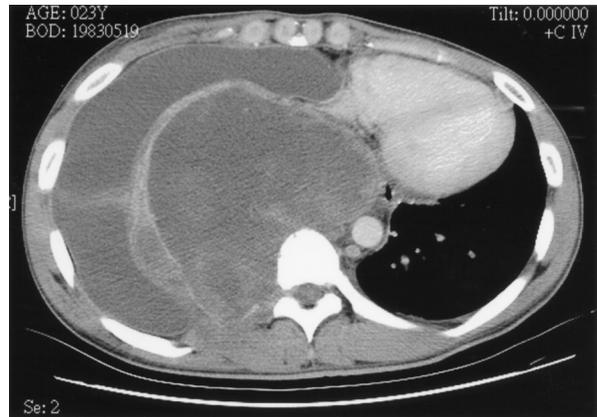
Chest computerized tomography (CT) demonstrating a huge soft tissue mass with heterogenous density and a necrotic area at the right posterior mediastinum. Massive pleural effusion in the right pleural cavity was also noted.
